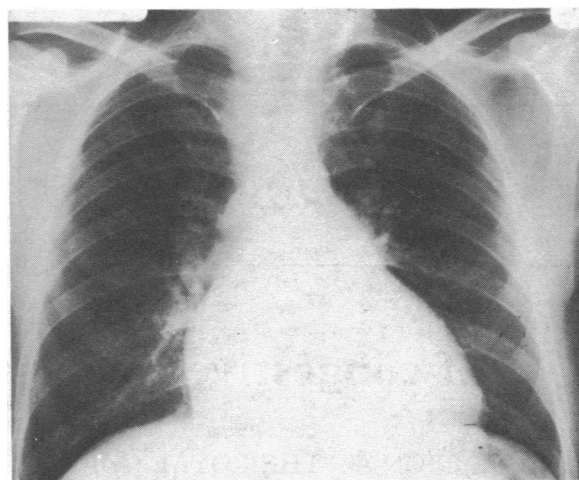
Chest radiograph taken on 25 June 1977 before re-admission.
